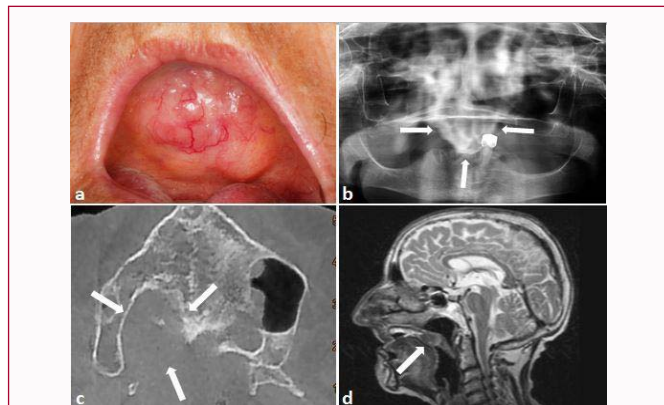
Preoperative images of case two, a: swelling in soft palate, b: Panoramic radiography, c: axial section on CBCT images, d: a well limited lesion in the middle of the soft palate with a radiolucent border in MRI.
